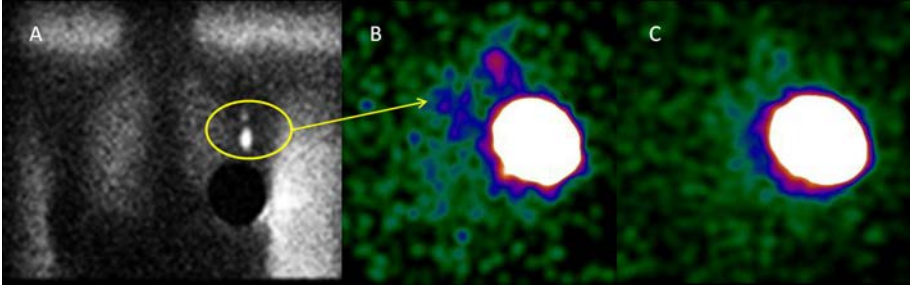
A 57 year old patient with a breast cancer in her left upper outer quadrant. Lymphoscintigraphic images acquired 2 h after intratumoural injection of 111 MBq of  $^{99m}\text{Tc}$  nanocolloid, showing two SLNs (yellow circle) (A). Image obtained using a portable gamma camera in the operating room before starting the SLN procedure, showing a similar scintigraphic pattern (yellow arrow) (B). Image acquired using the portable gamma camera after SLN excision, showing completeness of SLN removal (the residual large area of radioactivity accumulation corresponds to retention of the radiocolloid at the intratumoural injection site) (C).
